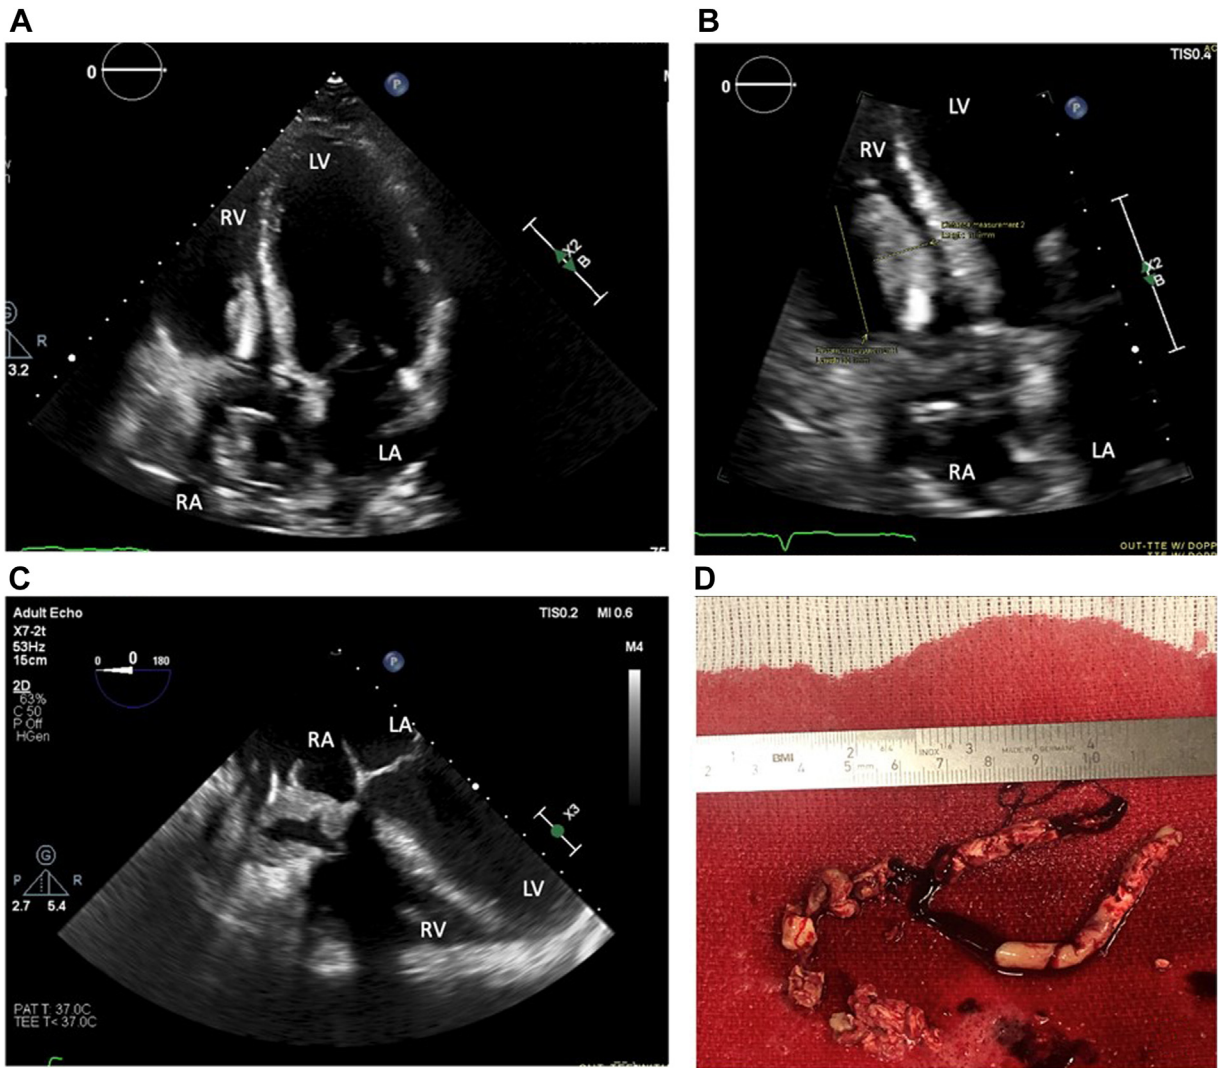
Case 3. A: Apical 4-chamber (A4C) view of lead-associated vegetation on transthoracic echocardiogram (TTE). B: Zoomed-in A4C view of 4.7 cm × 2.0 cm vegetation on TTE. C: Vegetation visualized on transesophageal echocardiography. D: Gross images of dense rubber-consistency vegetation after FlowTriever aspiration. Abbreviations as in Figure 2.
